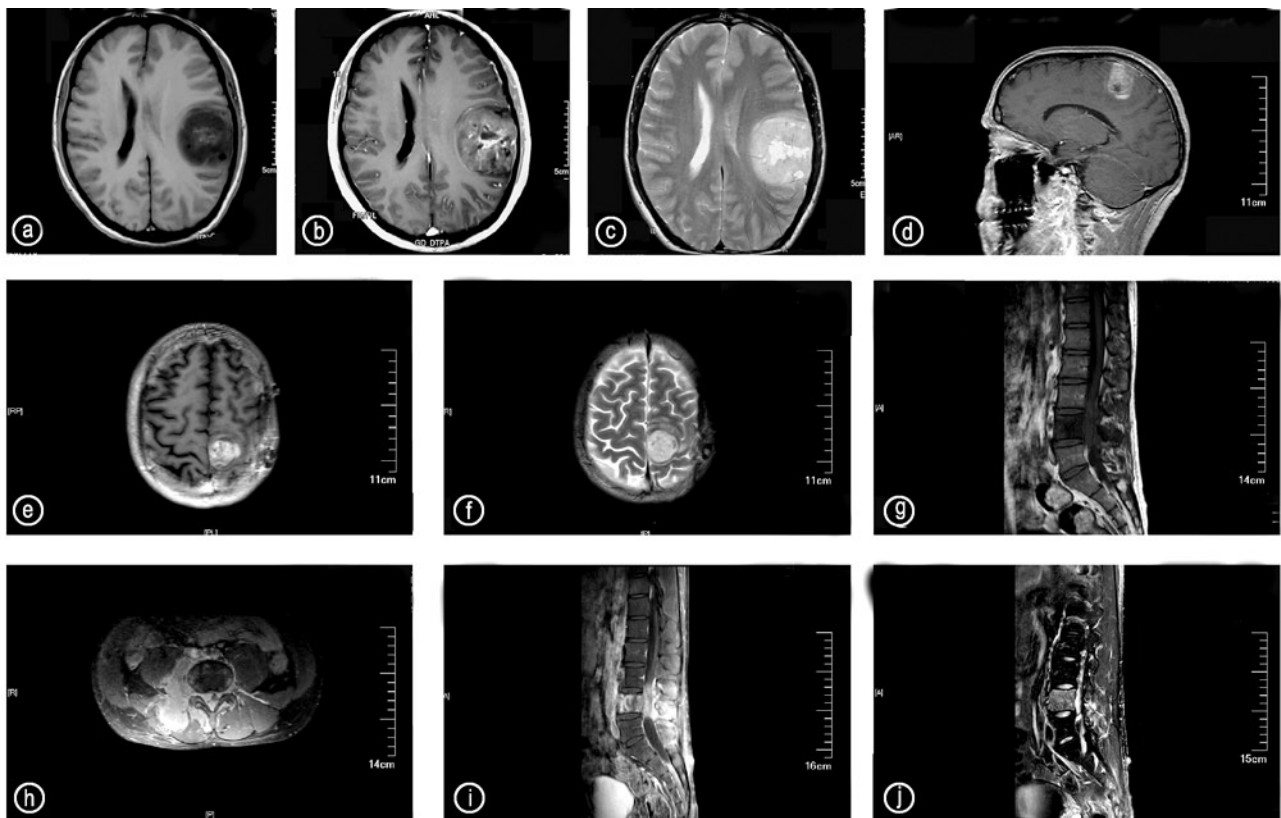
MRI scans of the different tumor locations. (a–c) The tumor preoperative of brain: T1 axial MRI (a), T1-weighted axial MRI (b) and T2 axial MRI (c); (d–f) A year and nine months later, MRI scan of the brain showed a local recurrence: T1-weighted coronal MRI (d), T1-weighted axial MRI (e) and T2 axial MRI (f); (g–j) MRI scan of the lumbar vertebra showed the metastasis: T1 coronal MRI (g), T1 axial MRI (h), T1-weighted coronal MRI (i) and T2 coronal MRI (j)
